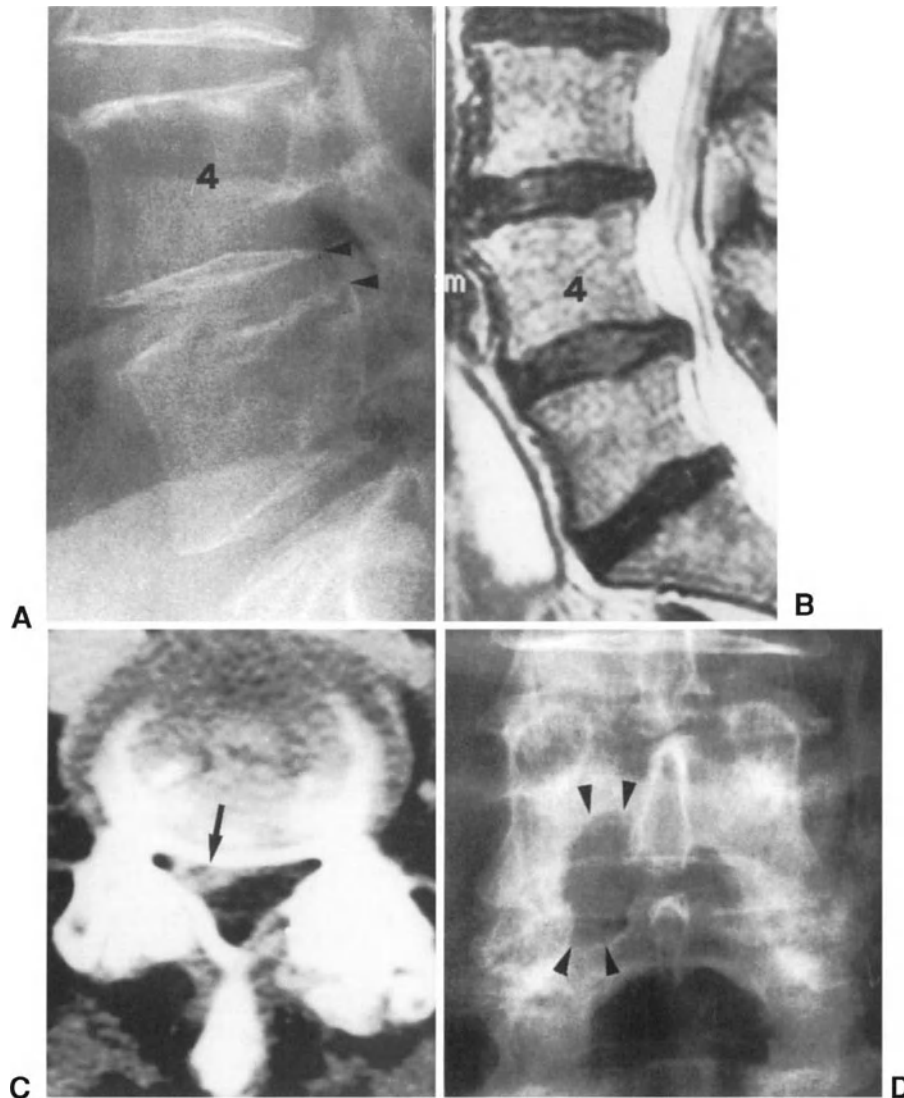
Degenerative spondylolisthesis and disc herniation. (A) Lateral radiograph showing mild degenerative spondylolisthesis of L4. (B) Spin-echo T2-weighted MR sagittal image revealing compression of the nervous structures due to spondylolisthesis of L4 and disc herniation at L4-L5 level. (C) Axial CT scan at L4-L5 level showing a small posterolateral herniation on the right (arrow). (D) Anteroposterior radiograph obtained after laminotomy and discectomy on the right. Laminotomy extends cranially until the distal third of L4 vertebral body and caudally to the distal portion of L5 pedicle (arrowheads).
